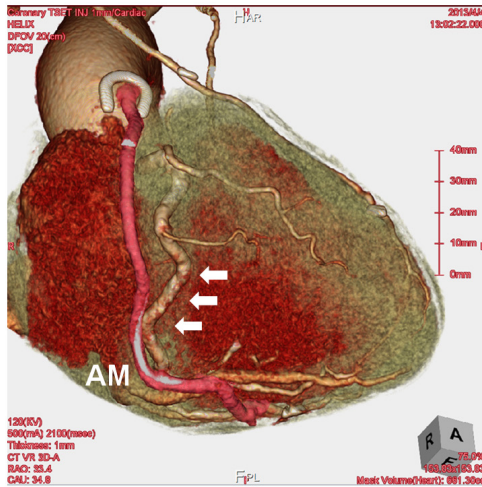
Three-dimensional computed tomography after the operation. A patent great saphenous vein graft (red-colored graft) was placed along the atrioventricular groove without kinking. The arrows indicate the right coronary artery. AM indicates the acute margin.
